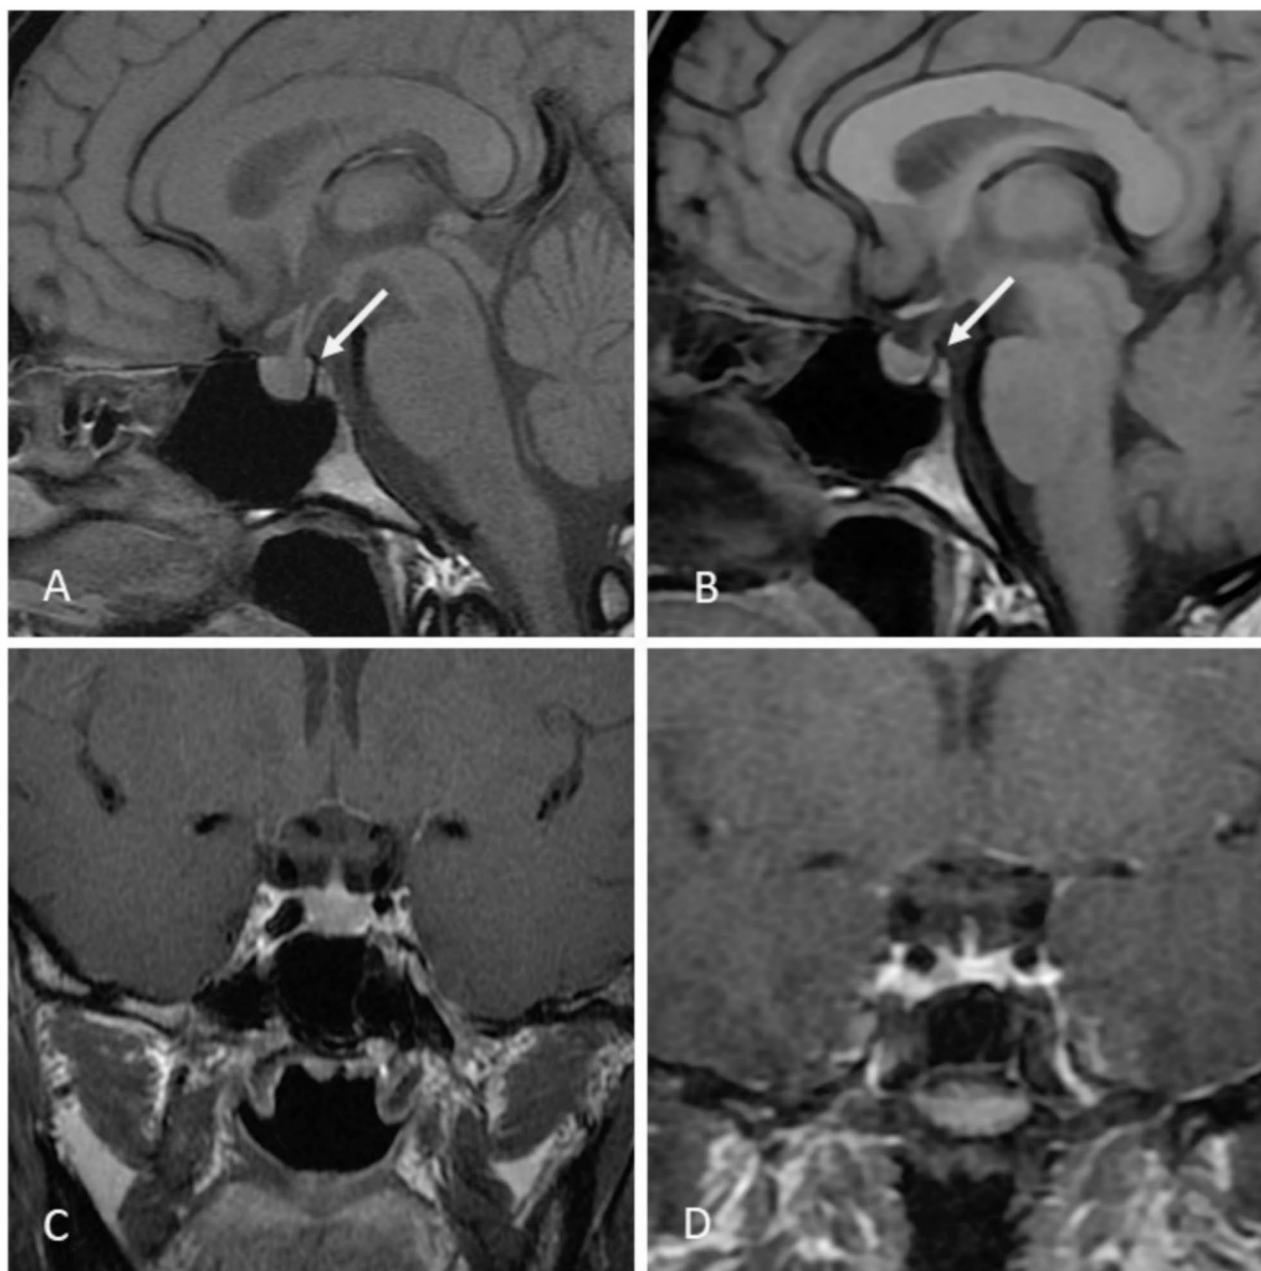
Magnetic resonance imaging scan of pituitary in sagittal view (A, B) and contrast-enhanced in coronal view (C, D), which were conducted at first month (A, C) and six months (B, D) since abortion, respectively. Both A and B showed an absence of posterior pituitary bright spot on the T1-weighted images. C showed slight pituitary hyperplasia in response to estrogen stimulation and recovered later (D)
